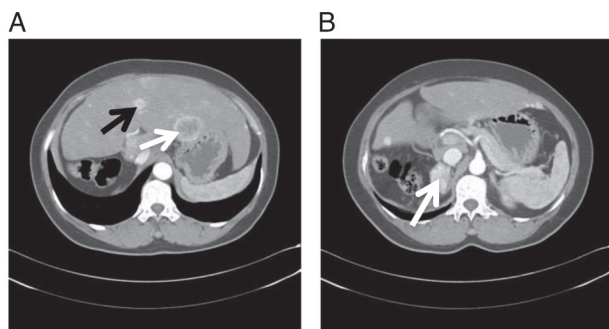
CT enhanced images of the upper abdomen at three years after surgery. (A) Hepatic arterial stage: The right lobe of the liver was absent. The left lobe of the liver increased in volume and there were multiple nodular (black arrow) and annular (white arrow) enhancements in the liver. (B) A mass in the right adrenal gland area was unevenly enhanced after enhancement (white arrow).
